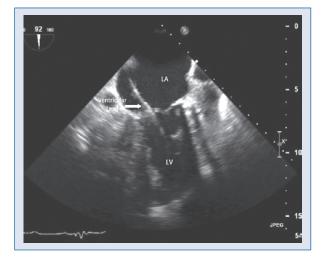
Transesophageal echocardiogram: ventricular lead fixed in the left ventricle (LV); LA — left atrium.
